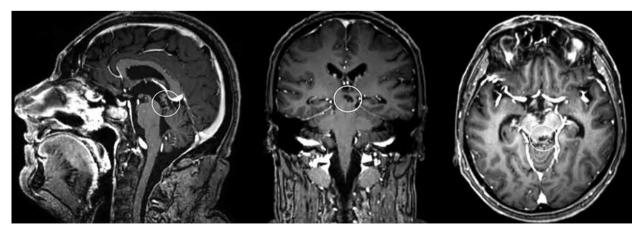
Magnetic resonance imaging of the brain with intravenous contrast 3 months after surgery: post surgery status of frontal transcortical transventricular removal of cavernous angioma in the cerebral aqueduct
